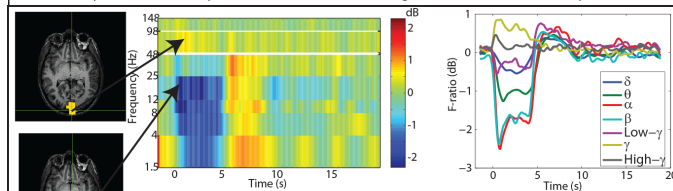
MEG results from same subject as in Figure 1. (Left) Overlays show power of gamma synchronisation (top) and beta desynchronisation (bottom) about 1s after stimulus onset. (Centre) Time-frequency plot shows F-ratio (dB) of power resulting from 4s stimulus at location in visual cortex indicated by crosshairs in both MRI overlays. (Right) Power changes averaged over all subjects.
